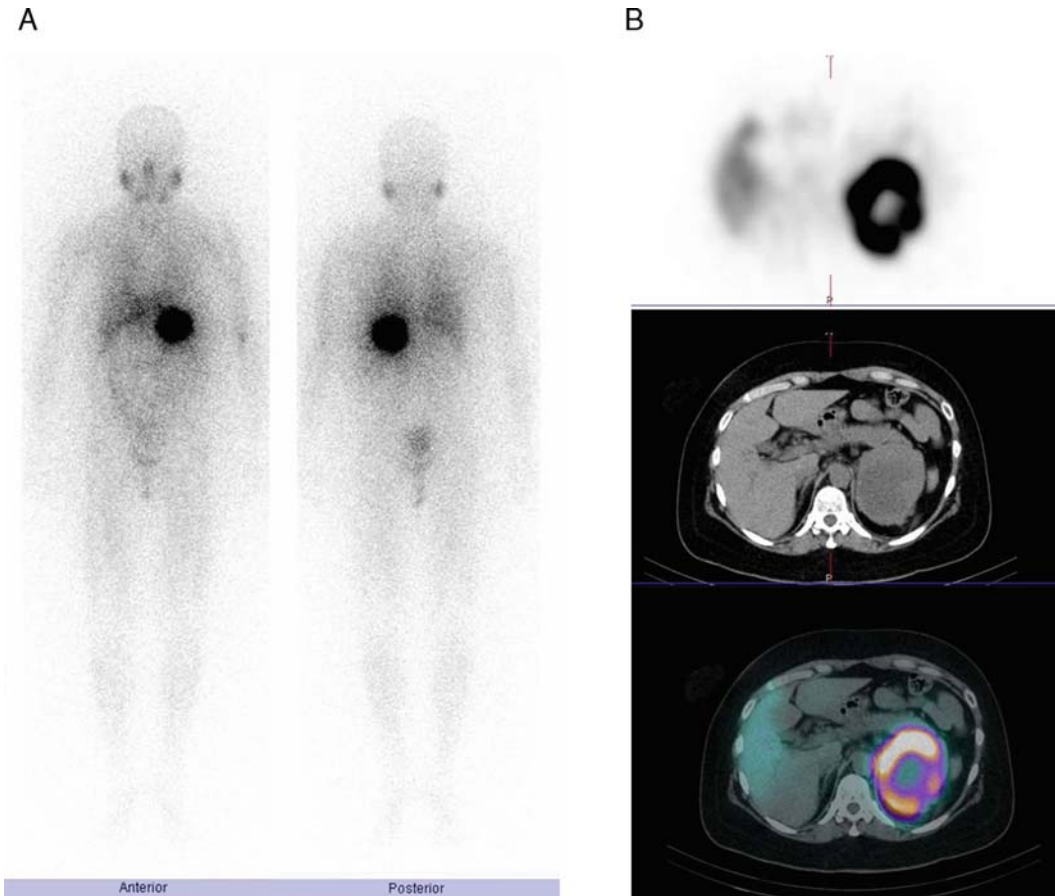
(A) Anterior and posterior whole-body views of an ^{123}I -MIBG scan done at 24 h after injection, in a middle age woman with pheochromocytoma. The MIBG avid tumor is visualized in the left adrenal gland. (B) Corresponding SPECT/CT of the abdomen, clearly delineating the rim of increased ^{123}I -MIBG activity to the large left adrenal mass. The center of the mass is not MIBG avid due to tumor necrosis. No distant metastases are visualized.
